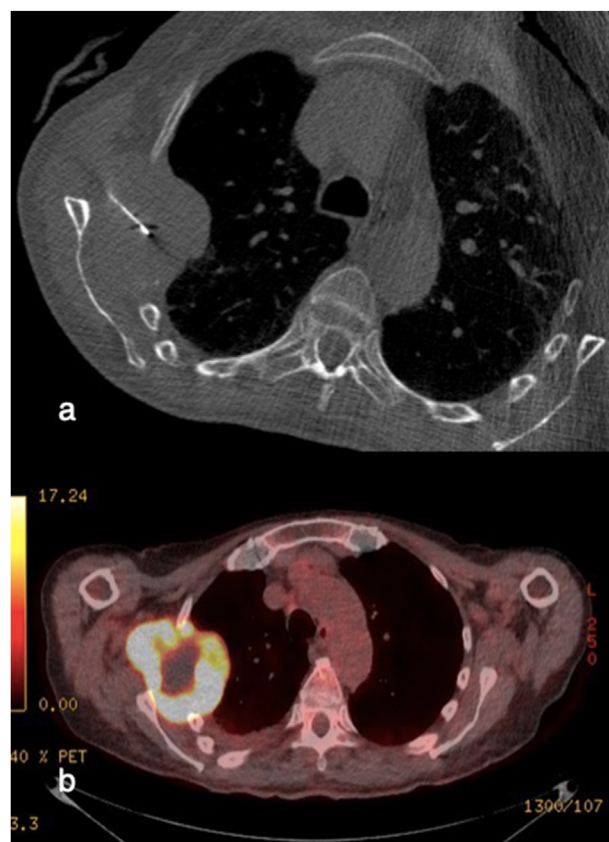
The value of PET-CT in identifying target regions for biopsy. An axial CT image of the thorax performed for CT-guided biopsy of a suspected right chest wall soft tissue sarcoma (a) was non-diagnostic. Note the trough of the biopsy needle lies within the centre of the lesion. A subsequent PET-CT (b) demonstrated a non-viable central region of tumour where the biopsy sample had been acquired. The FDG-avid regions at the periphery of the lesion (bright areas) reveal the regions of viable tissue likely to yield a diagnostic sample.
